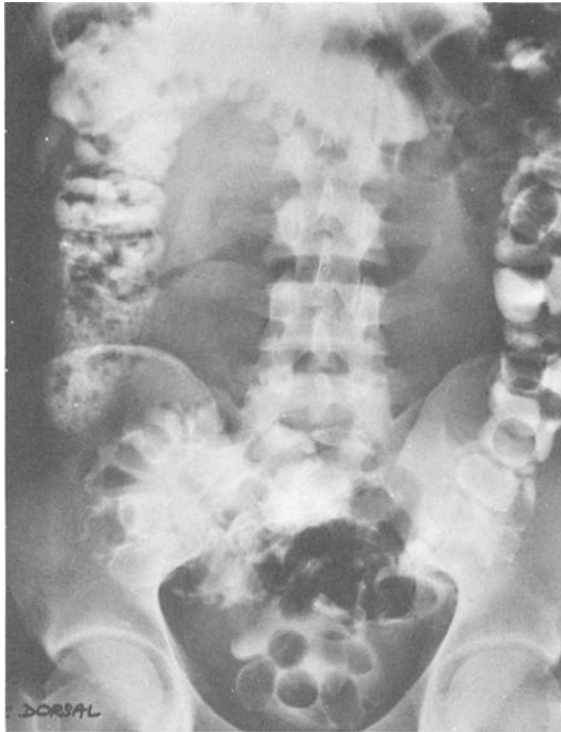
Supine abdominal roentgenogram performed 22 h after the administration of 50 mL of contrast compound showing numerous clarities outlined by the contrast in the left colon and rectum. Forty-eight packages remained to be eliminated.
